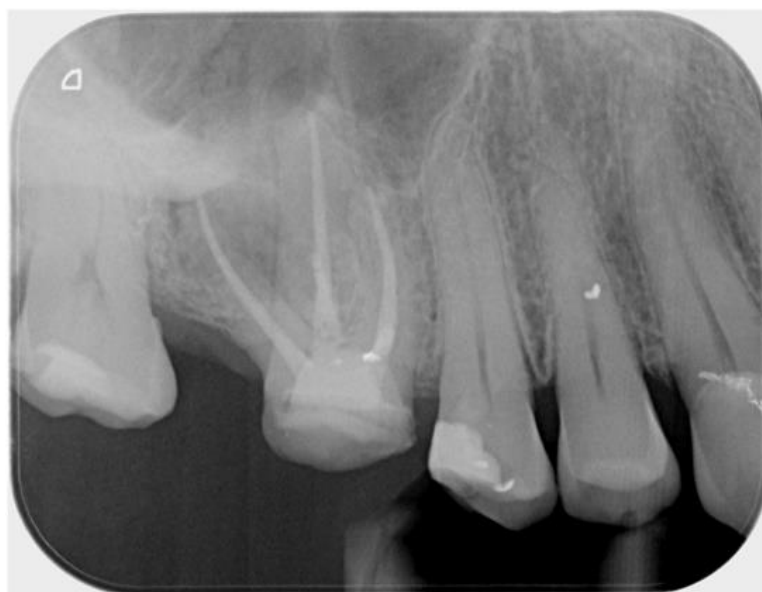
Case 4. Post Operative x-ray showing a completed root canal treatment and a direct restoration
